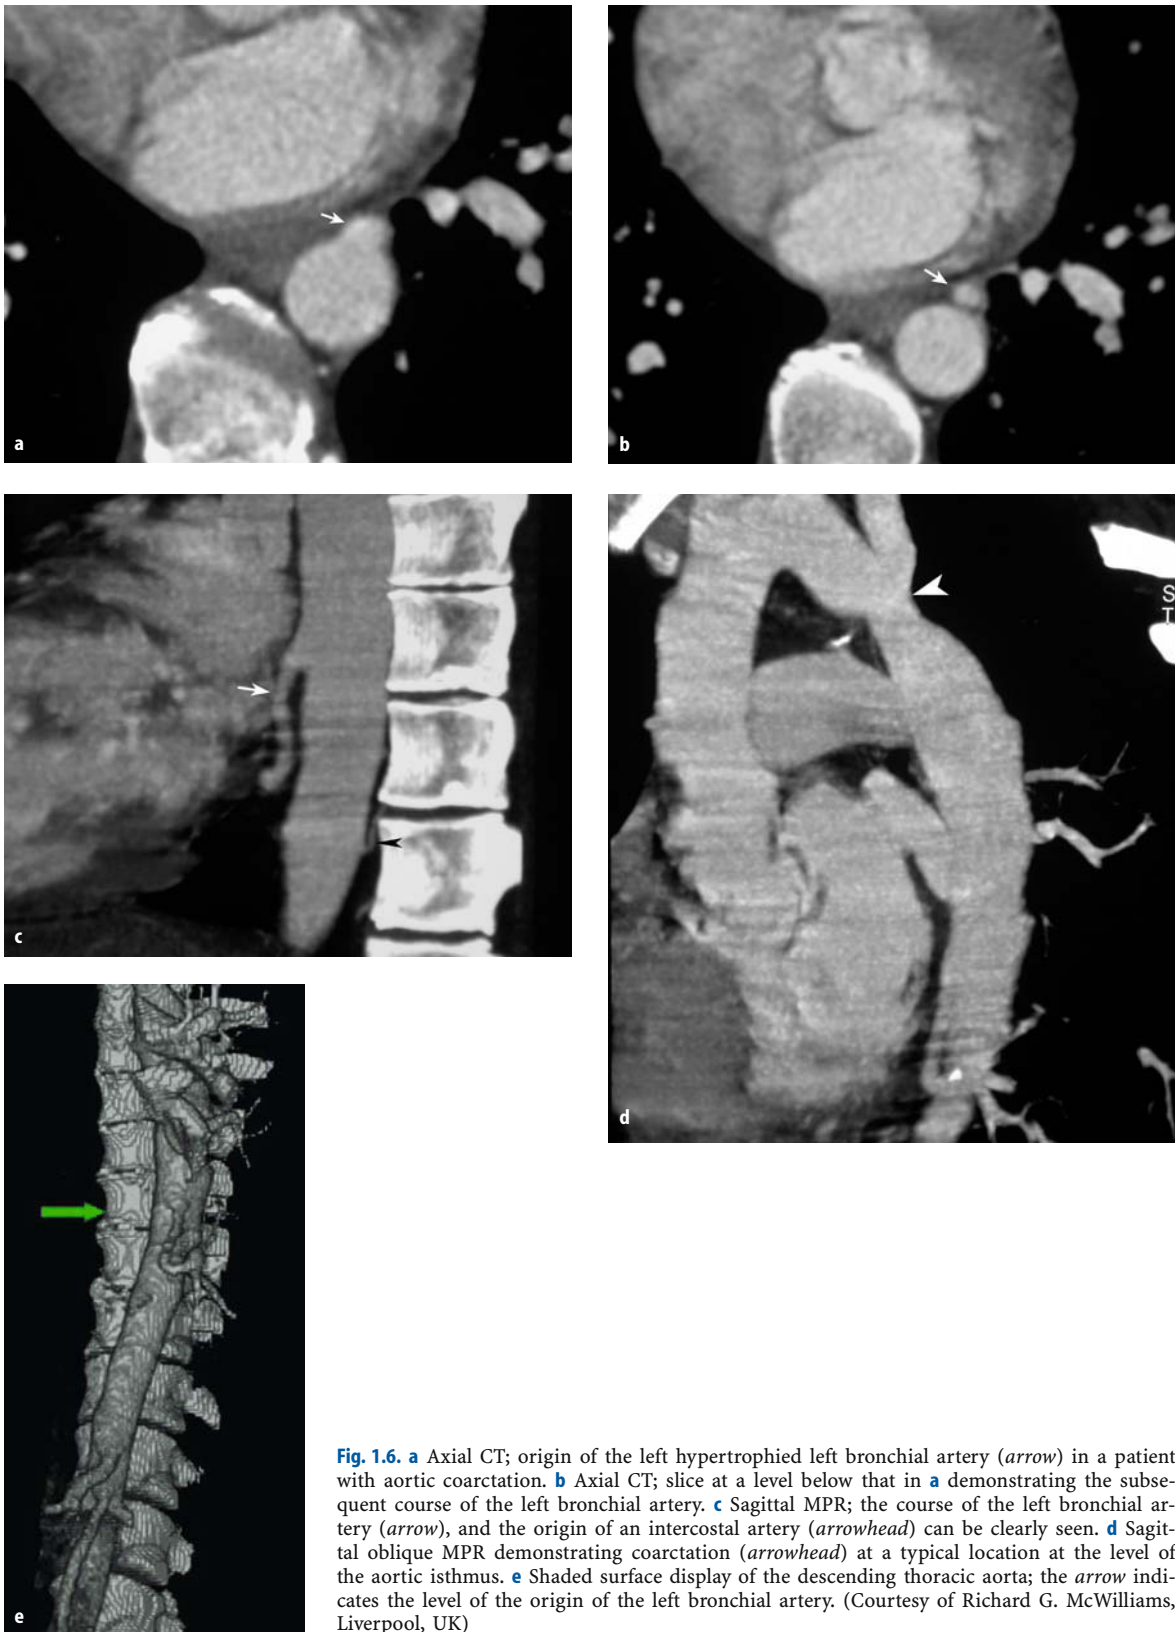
a Axial CT; origin of the left hypertrophied left bronchial artery (*arrow*) in a patient with aortic coarctation. b Axial CT; slice at a level below that in a demonstrating the subsequent course of the left bronchial artery. c Sagittal MPR; the course of the left bronchial artery (*arrow*), and the origin of an intercostal artery (*arrowhead*) can be clearly seen. d Sagittal-oblique MPR demonstrating coarctation (*arrowhead*) at a typical location at the level of the aortic isthmus. e Shaded surface display of the descending thoracic aorta; the *arrow* indicates the level of the origin of the left bronchial artery. (Courtesy of Richard G. McWilliams, Liverpool, UK)
